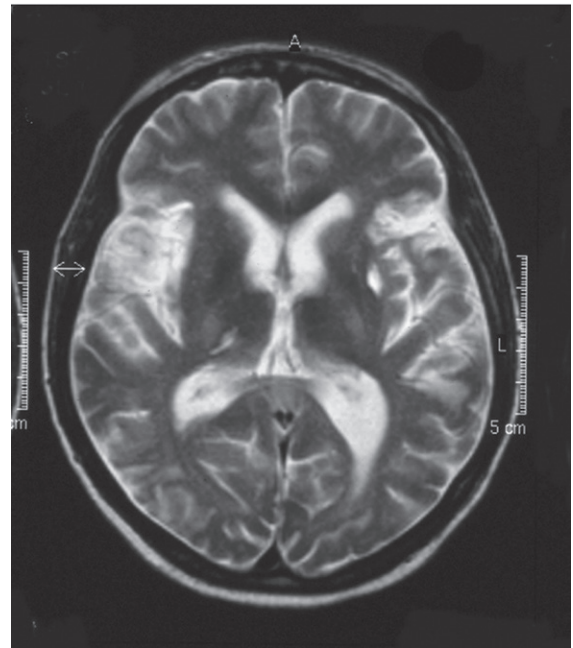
Magnetic resonance image of the brain in a patient with systemic lupus erythematosus and secondary antiphospholipid syndrome. The scan demonstrates significant cerebral atrophy as well as several areas of infarction from previous thrombotic episodes (strokes)
